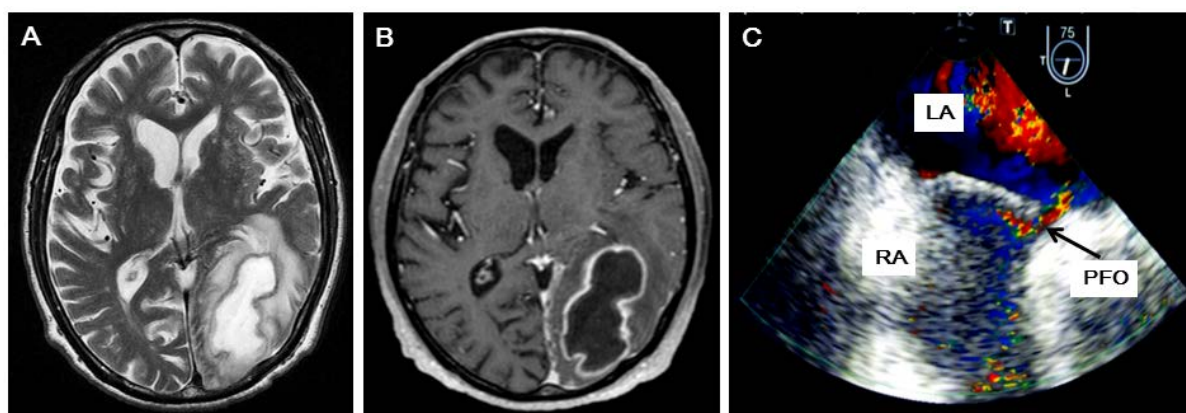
(A)-(C) Brain magnetic resonance image (MRI) with Geranium enhancement (A) and (B) and transesophageal echocardiogram (TEE) findings (C). (A) T2-weighted axial MR image showing a heterogeneous mass in the left occipital lobe, compressing the left lateral ventricle; (B) T1-weighted axial MR image with gadolinium enhancement, showing a left occipital hypointense mass lesion with ring enhancement; (C) TEE demonstrating PFO. A large right-to-left shunt identified by color Doppler analysis without Valsalva maneuver. RA: right atrium, LA: left atrium.
